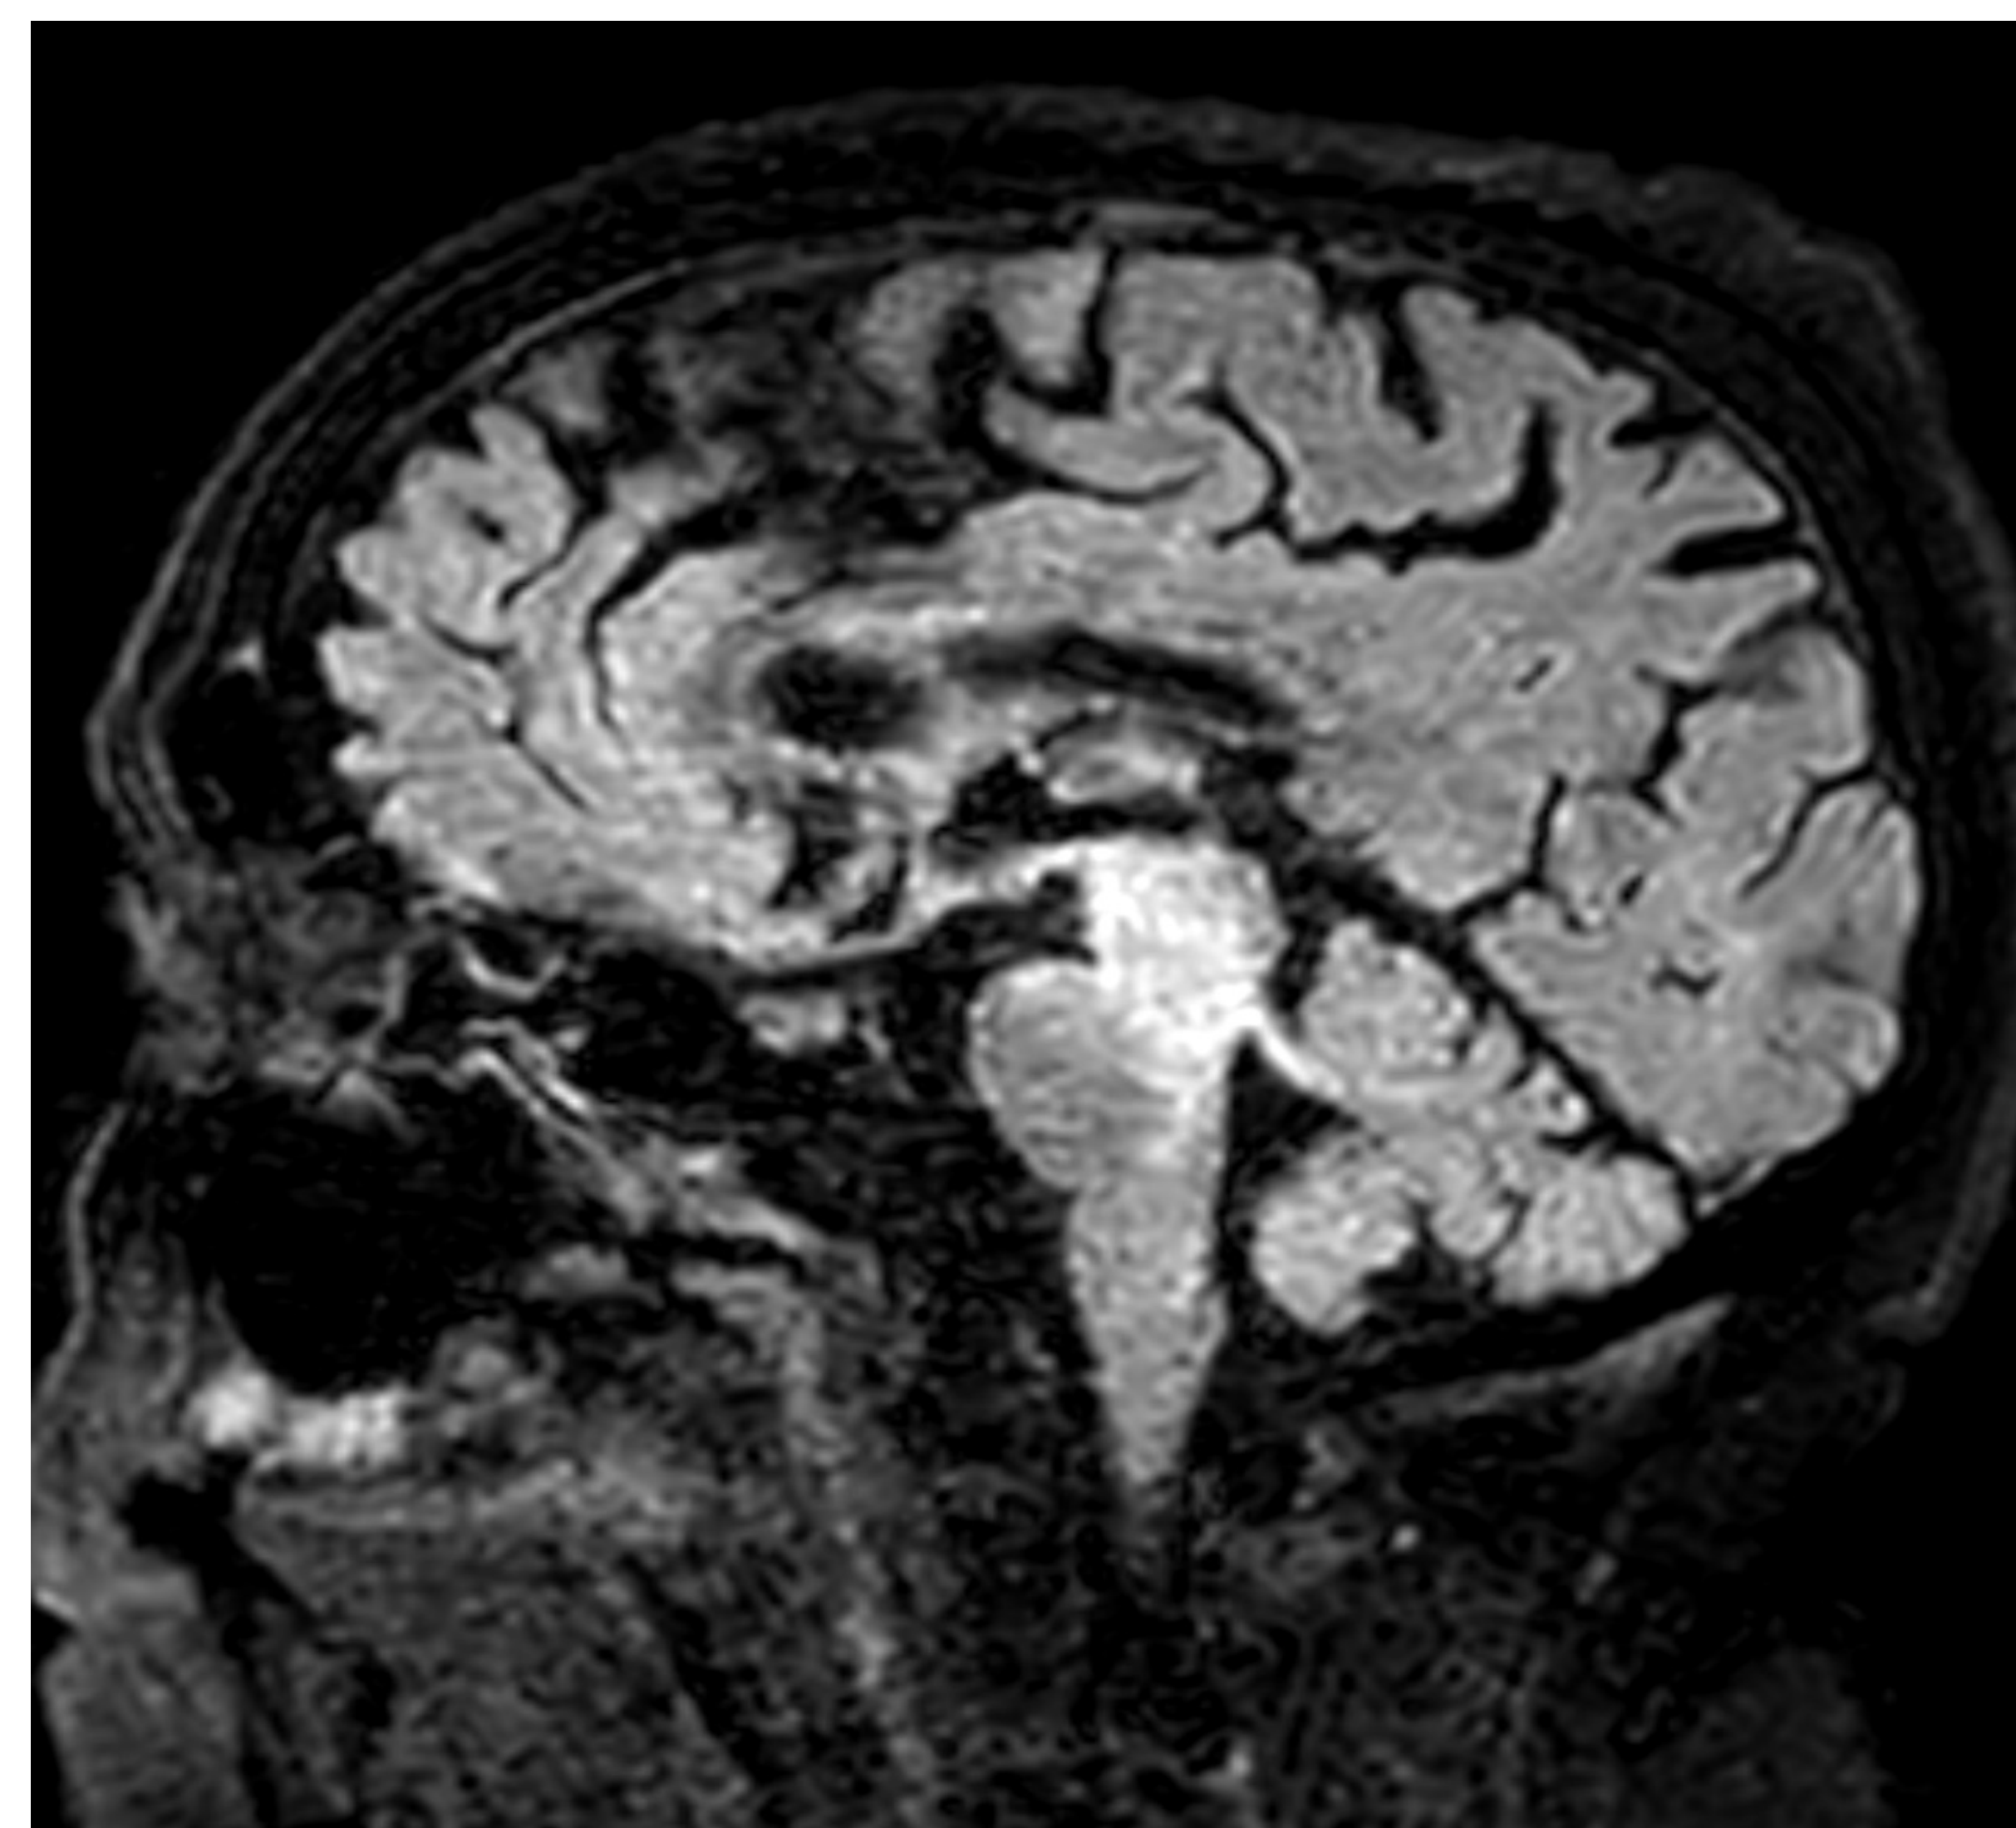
Sagittal T2 FLAIR sequence through the midline of the brain shows confluent T2 hyperintense signal in the brainstem, extending along the dorsal pons (outlined in blue dashed line).
